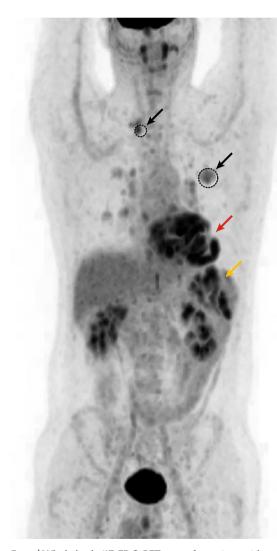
Whole body ¹⁸F-FDG-PET scan of a patient with sarcoidosis. ¹⁸Fluor-fluorodeoxyglucose-PET (¹⁸F-FDG-PET) image showing pulmonary (black arrows), cardiac (red arrow) and spleen (yellow arrow) localization of inflammatory lesions due to sarcoidosis. Image courtesy of R. G. M. Keijsers, St Antonius Hospital, Netherlands.
